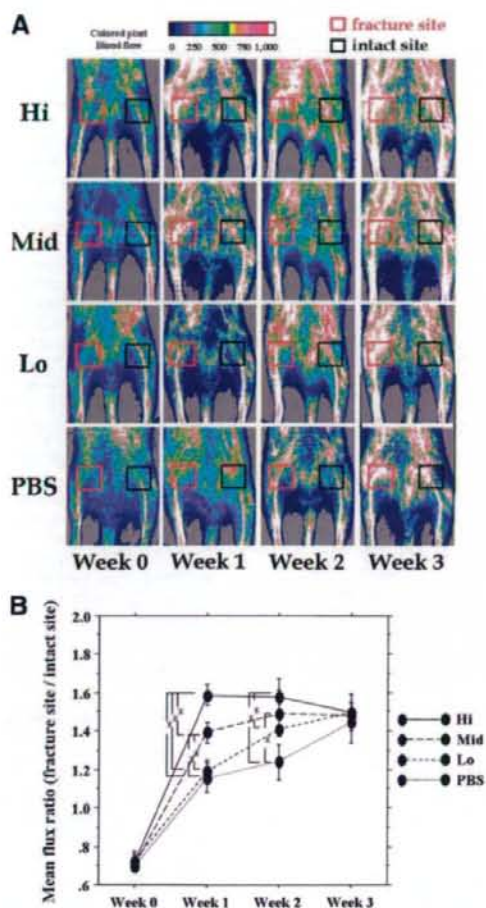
Improvement of blood flow at fracture sites following CD34+ cell transplantation. (A): Representative laser Doppler perfusion imaging (LDPI) at week 0 (1 hour after fracture), 1, 2 and 3 are shown. In these digital color-coded images, maximum perfusion values are indicated in white, medium values in green to yellow, and lowest values in dark blue. The skin blood flow within fracture site (red square) and intact contralateral site (black square) were evaluated as mean flux, and the ratio of the mean flux in the fractured site to that in the contralateral site (mean flux ratio) was calculated. (B): Severe reduction of the blood flow was observed 1 hour after nonhealing fracture was created (week 0) in all groups, whereas the mean flux ratio at week 1 was significantly higher in the Hi group compared with other groups, as well as in the Mid group compared with the Lo and PBS groups. At week 2, the ratio was significantly higher in the Hi group compared with the Lo and PBS groups, as well as in the Mid group compared with the PBS group. *, $p < .05$. Abbreviations: Hi, 10^5 ; Lo, 10^3 ; Mid, 10^4 ; PBS, phosphate-buffered saline.
